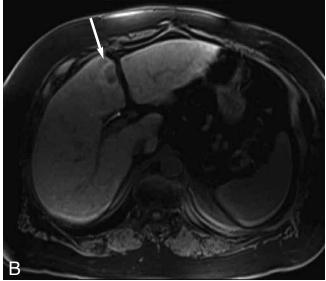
MRI of the liver during arterial phase (20 sec) and delayed (15 min) after IV administration of Eovist. The enhancing lesion appears hypointense on the delayed phase, consistent with metastases from thyroid cancer.
